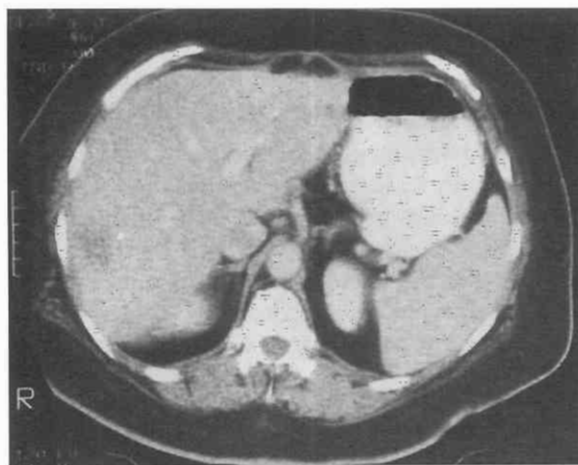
Inferior vena cava pseud thrombus. Early images on this dynamically enhanced CT scan demonstrate centrally, not yet enhanced inferior vena cava blood from the pelvis and lower extremities, surrounded by already enhanced blood from the renal veins. On delayed images, the inferior vena cava became homogeneous. Low-attenuation liver lesions are also present.
